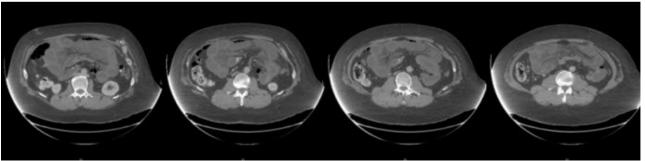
51 year old male with closed loop bowel obstruction secondary to internal hernia. Axial CT series demonstrating the segment of decompressed bowel and "mushroom sign".
